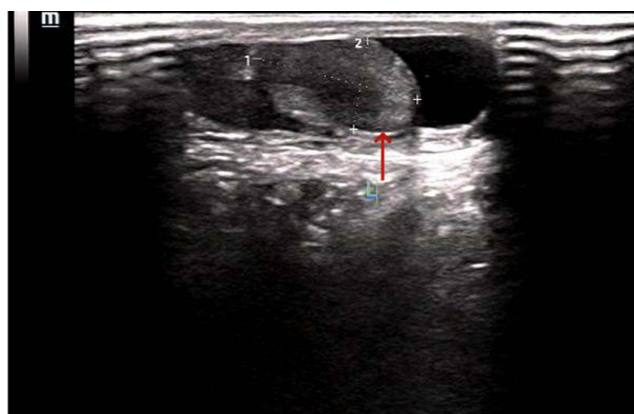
Ultrasound shows anechoic fluid surrounding the left testicle (red arrow), with an approximate size of 2.1×1.0 cm.
